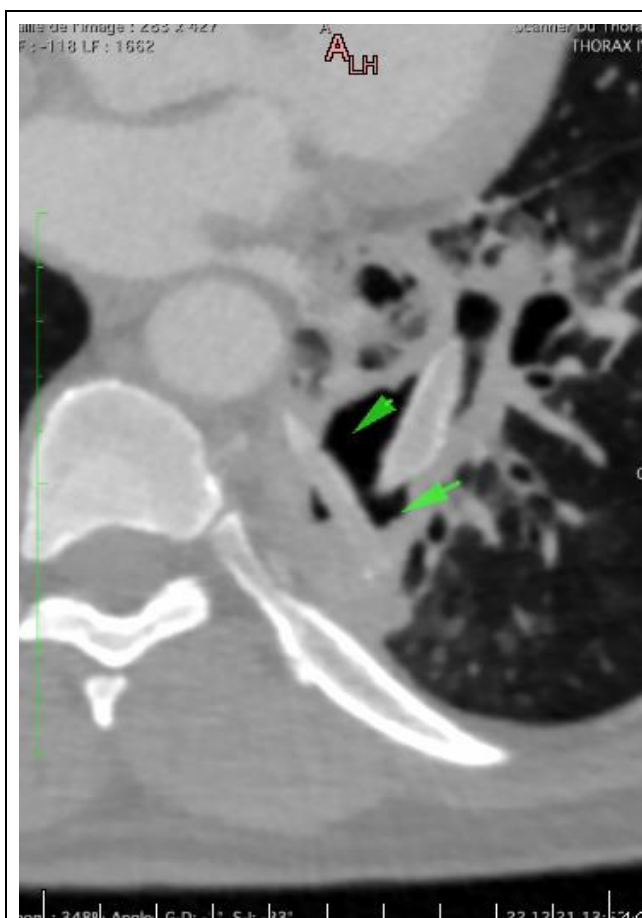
Axial CT image showing two hyperdense foreign bodies within a cavitory lesion of the left lower lobe.
